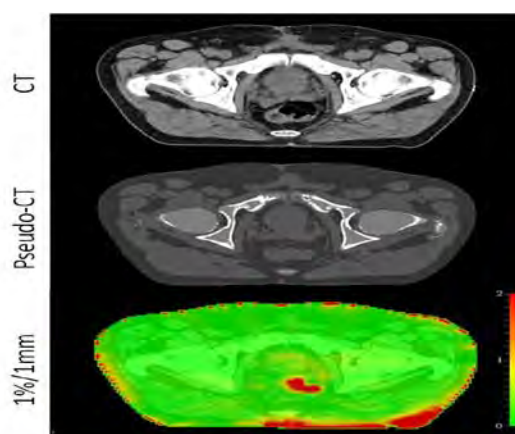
Corresponding slice on CT and pseudo-CT and gamma analysis of respective dose calculations.
